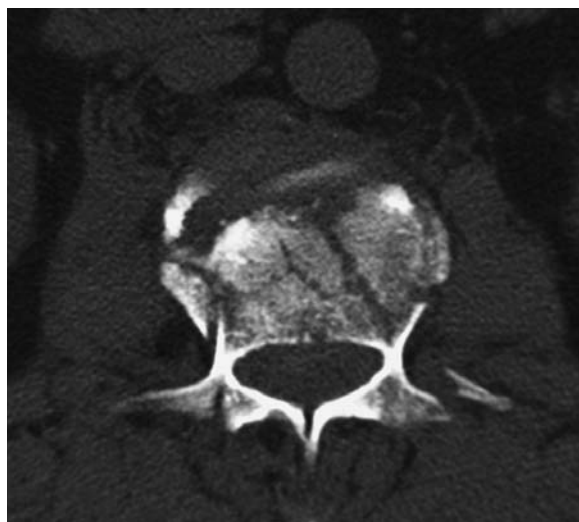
Burst fracture. Axial CT demonstrates the comminuted fracture fragments without retropulsion into the canal, transverse process fractures, and the typical green stick laminar fracture
